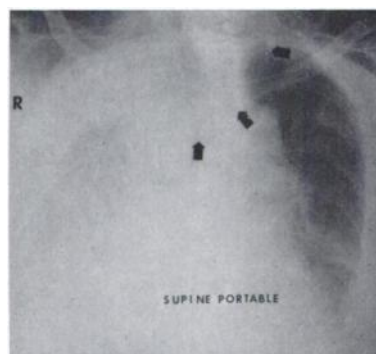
Portable supine chest radiograph obtained 12 hr after Fig. 3, and 30 min after V/Q image (Fig. 4). Progressive increase in extrapleural fluid is evident.
